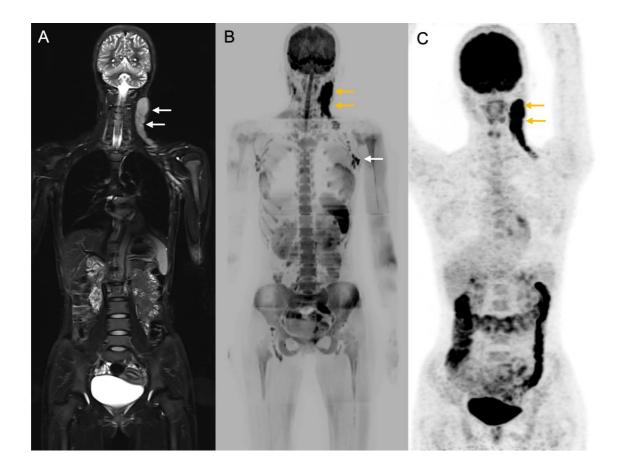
Stage I on both WB-MRI and PET-CT. A. Coronal STIR image showing hyperintense, enlarged lymph nodes in the left cervical level II-V region (white arrows). B. Coronal MIP DWI image showing, enlarged lymph nodes in the left cervical level II-V region which are showing diffusion restriction (yellow arrows). A few reactive left axillary lymph nodes are also seen. C. Coronal MIP PET image showing enlarged lymph nodes in the left cervical level II-V region which are showing enlarged level II-V region which are showing enlarged lymph nodes are also seen. C. Coronal MIP PET image showing EDG uptake (yellow arrows).
